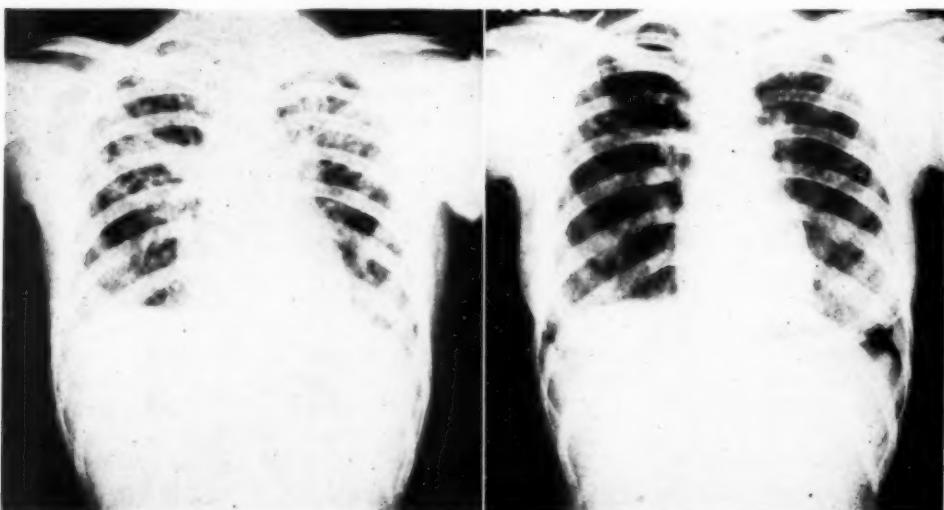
Case 2. Roentgenograms of chest. A. Dec. 27, 1946. B. Aug. 4, 1947. Discussed in text.
